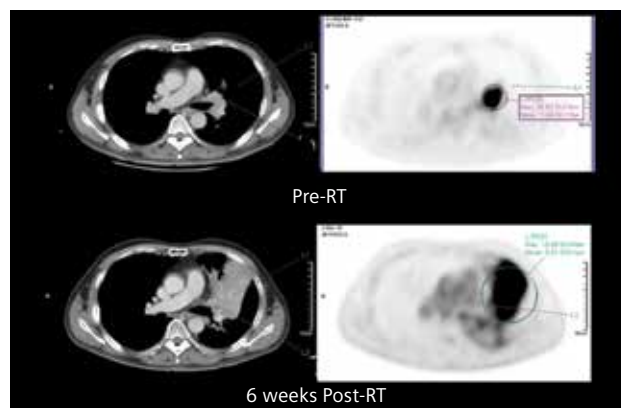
CT and PET transverse slices at the level of the left hilar tumor compared to pre- and post-radiation therapy (RT). PET/CT show a smaller hypermetabolic hilar mass in the pre-therapy PET (SUV<sub>max</sub> 14.8), with a large area of consolidation and avid glucose uptake (SUV<sub>max</sub> 10.8) involving the entire lobar segment seen in the post-therapy PET/CT, secondary to post-radiation inflammation. The comparison between the two scans and the uptake suggests resolution of the tumor with superimposition of the uptake related to the post-radiation inflammation.
